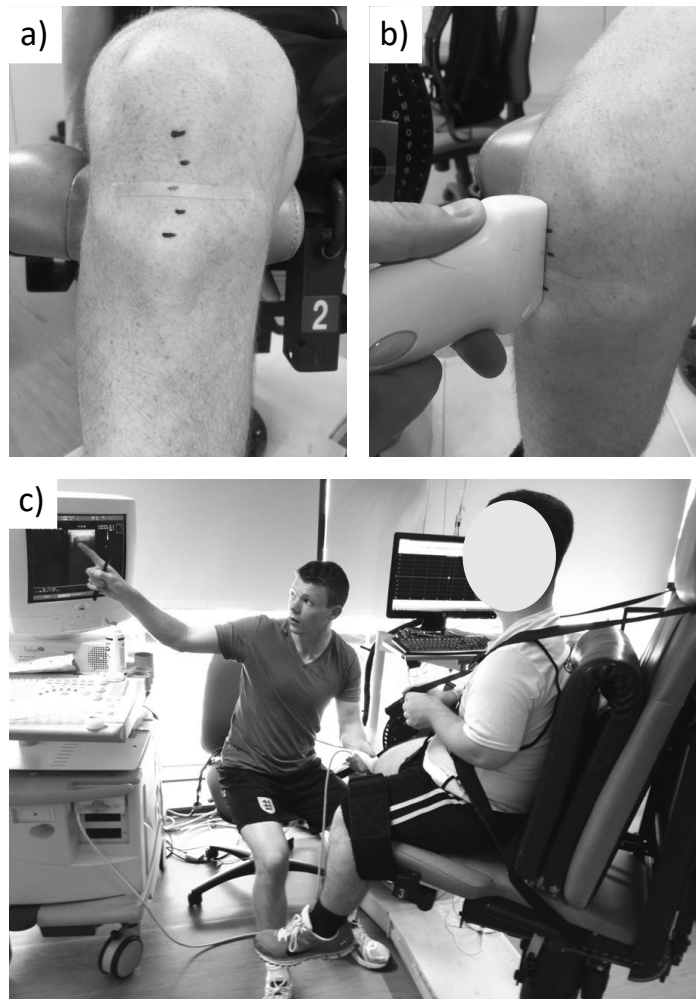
a) proximal (top) and distal (bottom) markers that identify absolute and proportionally patella tendon lengths for a control participant, b) ultrasound probe placement that observes the proximal and reference marker (echo absorbing tape) for a control participant, and c) a participant with Achondroplasia in the experimental set up with a feedback monitor.
